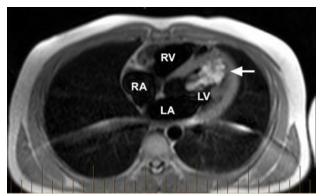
Cardiac magnetic resonance image of LV myxoma
